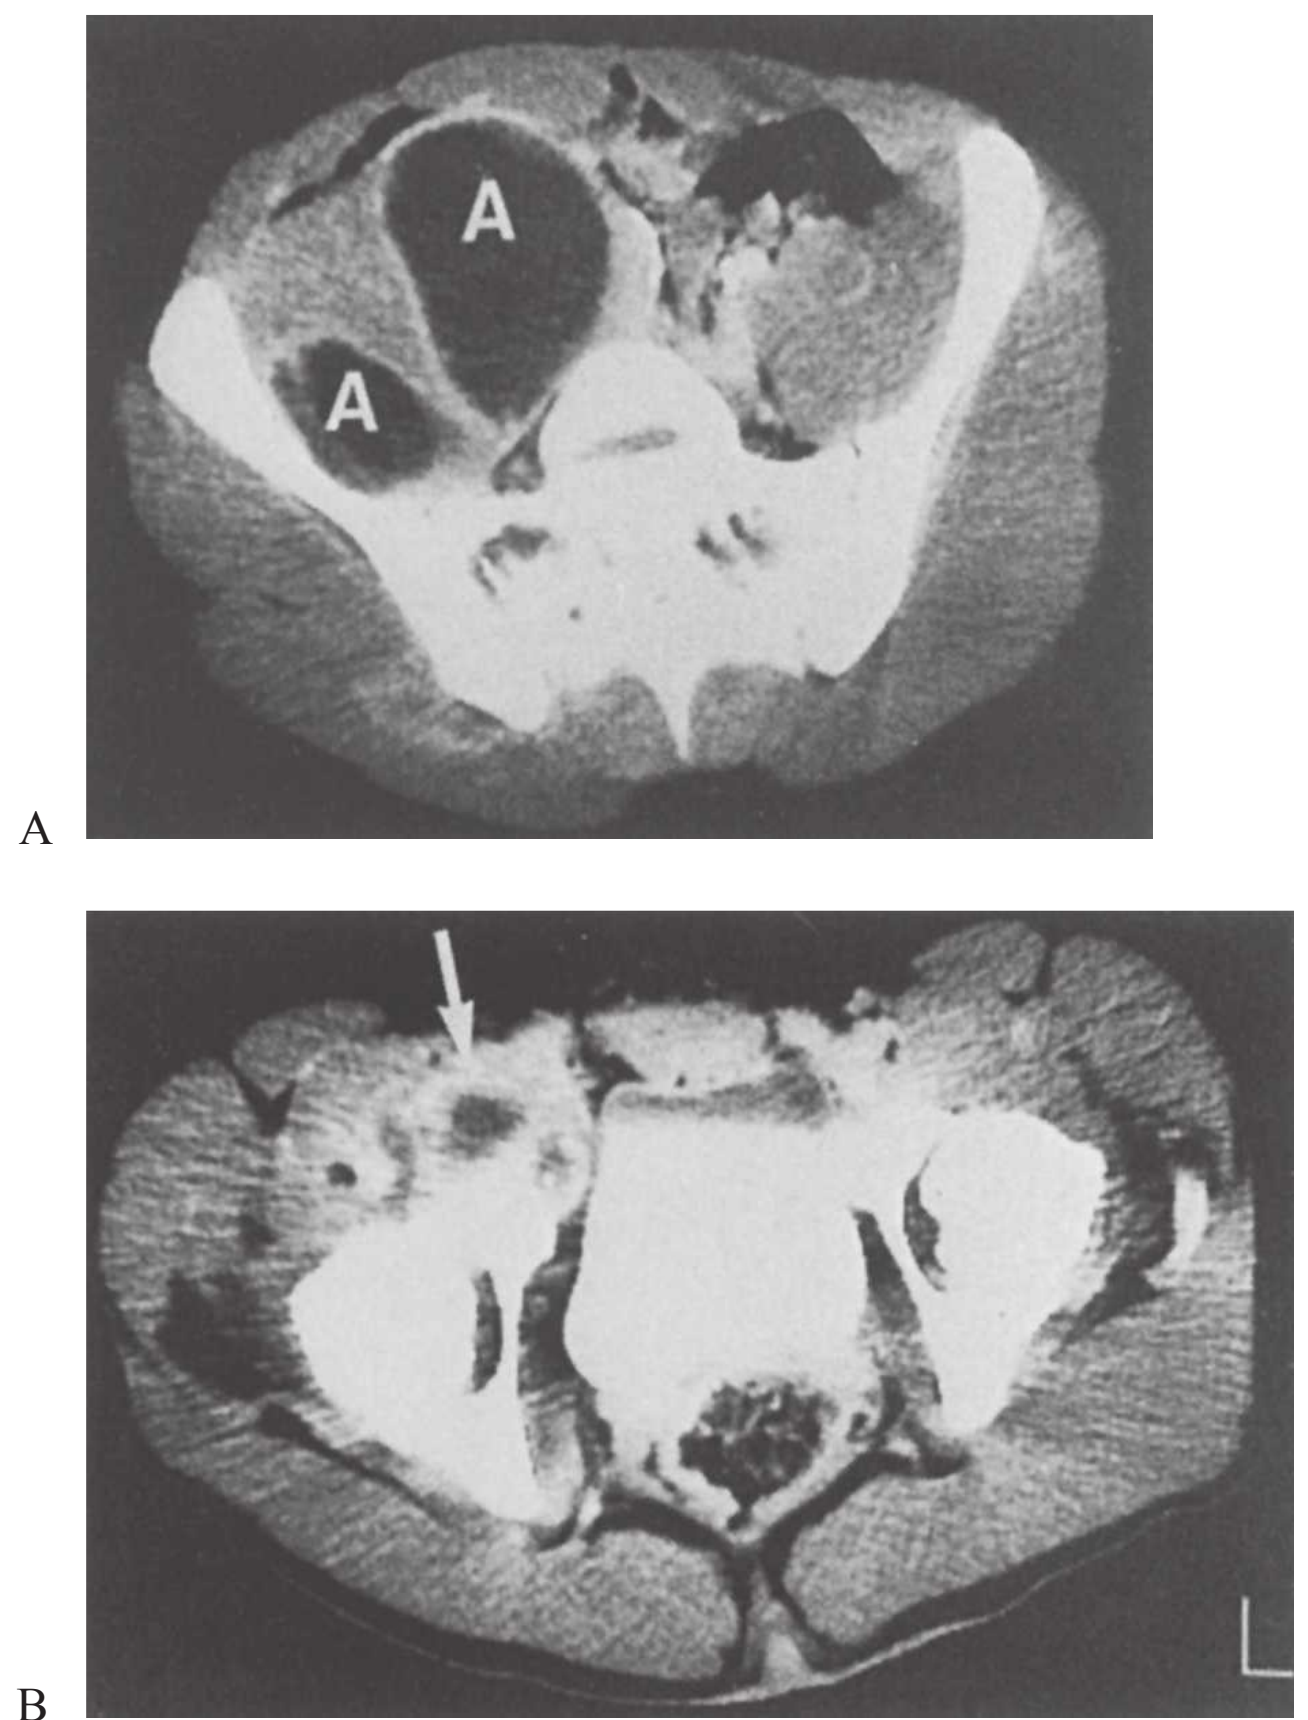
A: Computed tomography (CT) scan through midabdomen, demonstrating marked enlargement of the right psoas major muscle with a bilobed fluid-filled cavity, labeled *A* (from the same patient as in Fig. 24.8). B: Transverse CT scan through the level of the femoral head, showing the inferior extent of the abscess (*arrow*) pointing below the inguinal ligament. (From Andriole VT. The clinician's viewpoint. *Clin Diagn Ultrasound*. 1982;11:1, with permission.)
